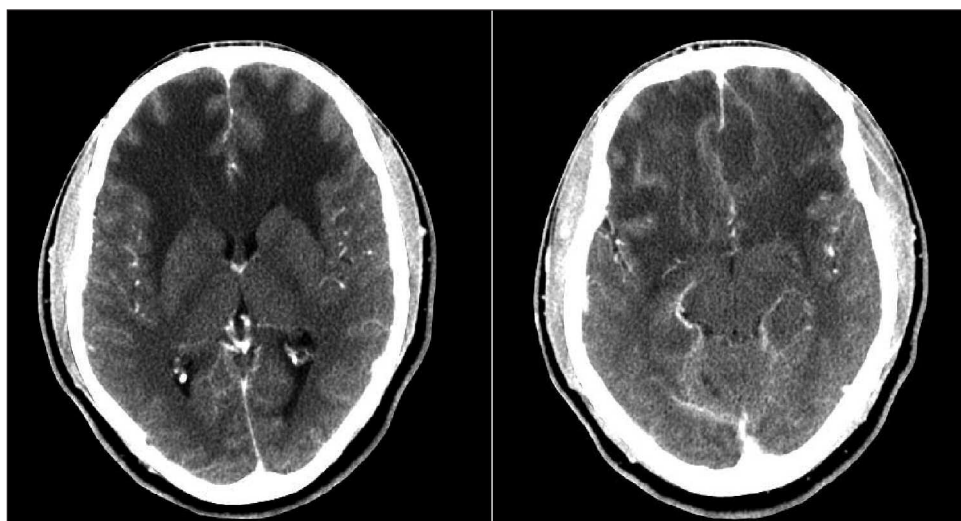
Two transverse computed tomography slices on the frontal lobe and near the anterior skull base, after contrast injection, showing bilateral extensive hypodensity of the frontal white matter with mass effect.
